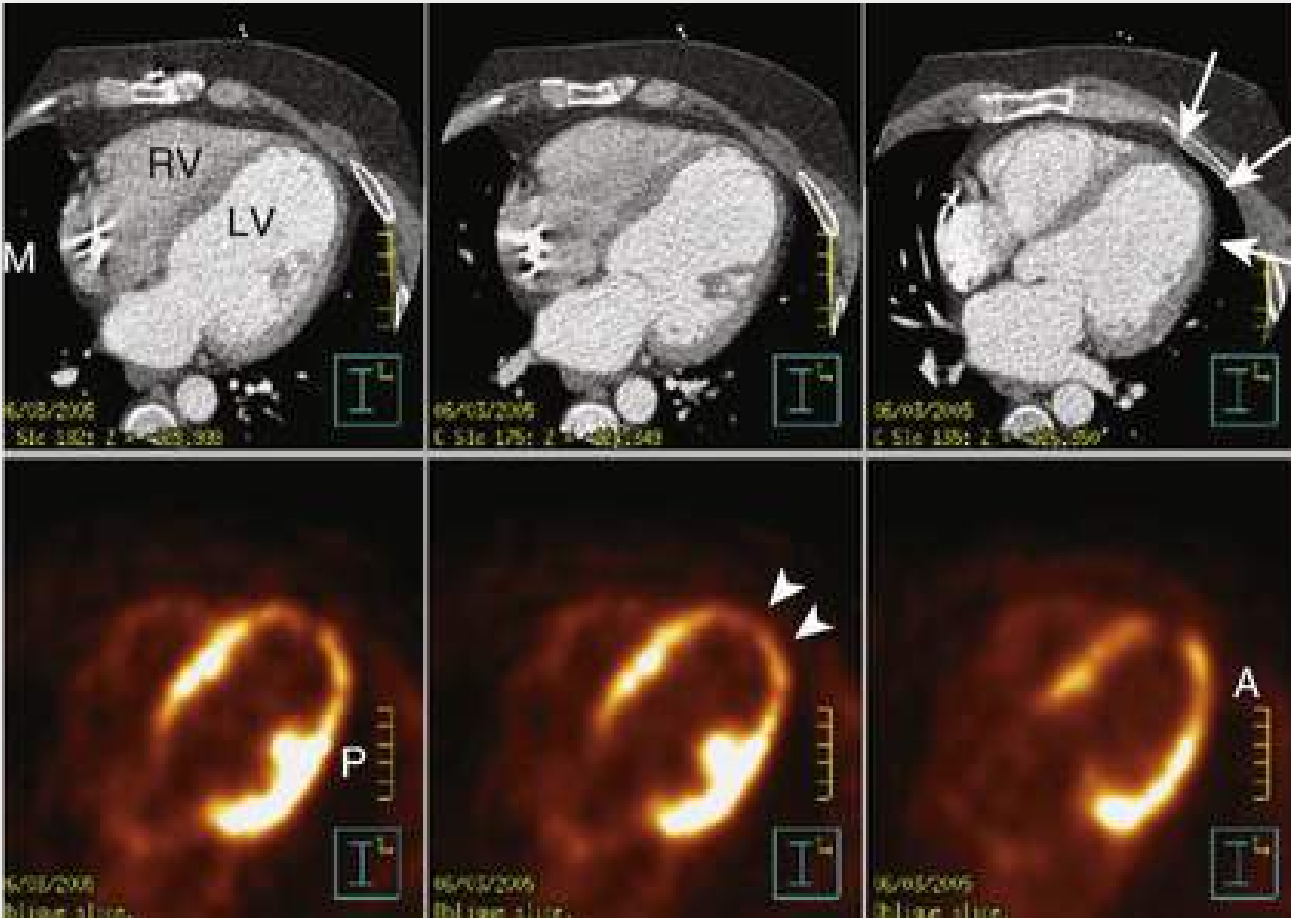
^{18}F -FDG PET and CT imaging to identify substrate for ventricular arrhythmias in heart failure. Top row, Contrast-enhanced CT demonstrates all cardiac chambers. *RV*, Right ventricle; *LV*, left ventricle; *M*, metal artifact of internal defibrillator lead in right atrium. Significant wall thinning (*arrows*) is noted in the apical and lateral LV wall, consistent with myocardial infarction. Bottom row, FDG PET images show a matching decrease in signal intensity in apical and lateral wall segments (*arrowheads*). Preserved metabolism of papillary muscle (*P*) was noted. Note the areas of partially preserved metabolic activity (*A*) within the lateral wall, which appears uniformly thinned on CT images and may represent surviving myocardium within the infarcted area. (Modified from Dickfeld T, Lei P, Dilsizian V, et al. Integration of three-dimensional scar maps for ventricular tachycardia ablation with positron emission tomography-computed tomography. *J Am Coll Cardiol Imaging* 2008;1:73-82.)
